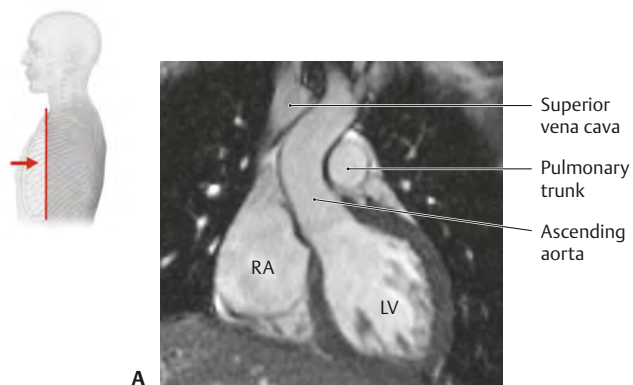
Coronal section through heart and similar MRI
